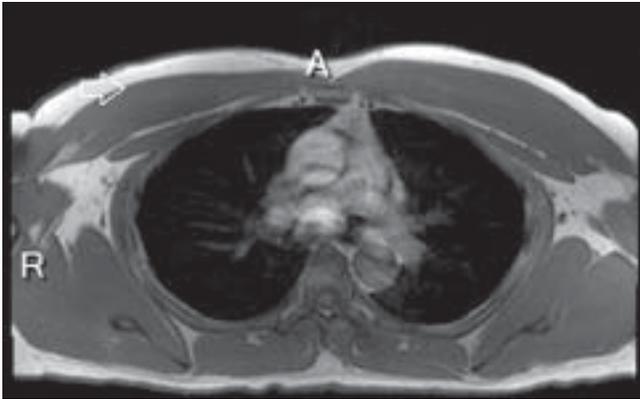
MRI of the Chest Wall Revealing Thinning of the Right Pectoralis Muscle (White Arrow)
